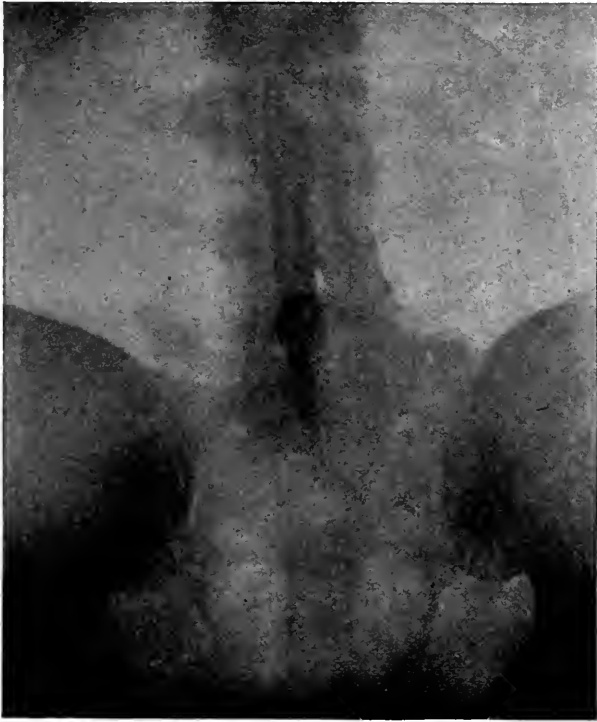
This roentgenograph shows the satisfactory proliferation of a bone-graft inserted six months previously for tuberculosis of the fifth lumbar vertebra. The graft was contacted with the third and fourth lumbar vertebræ above and the first and second sacral segments below the lesion.
